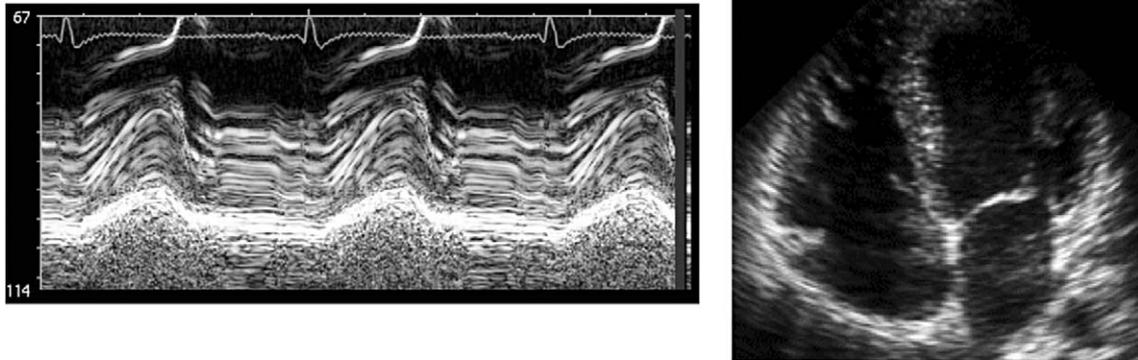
Echocardiography images. (Left) M-mode. (Right) B-mode image from a four-chamber sequence, at end-systole (video available at <http://www.die.upm.es/im/videos>). Courtesy of Hospital G.U. Gregorio Marañón (Madrid, Spain).
